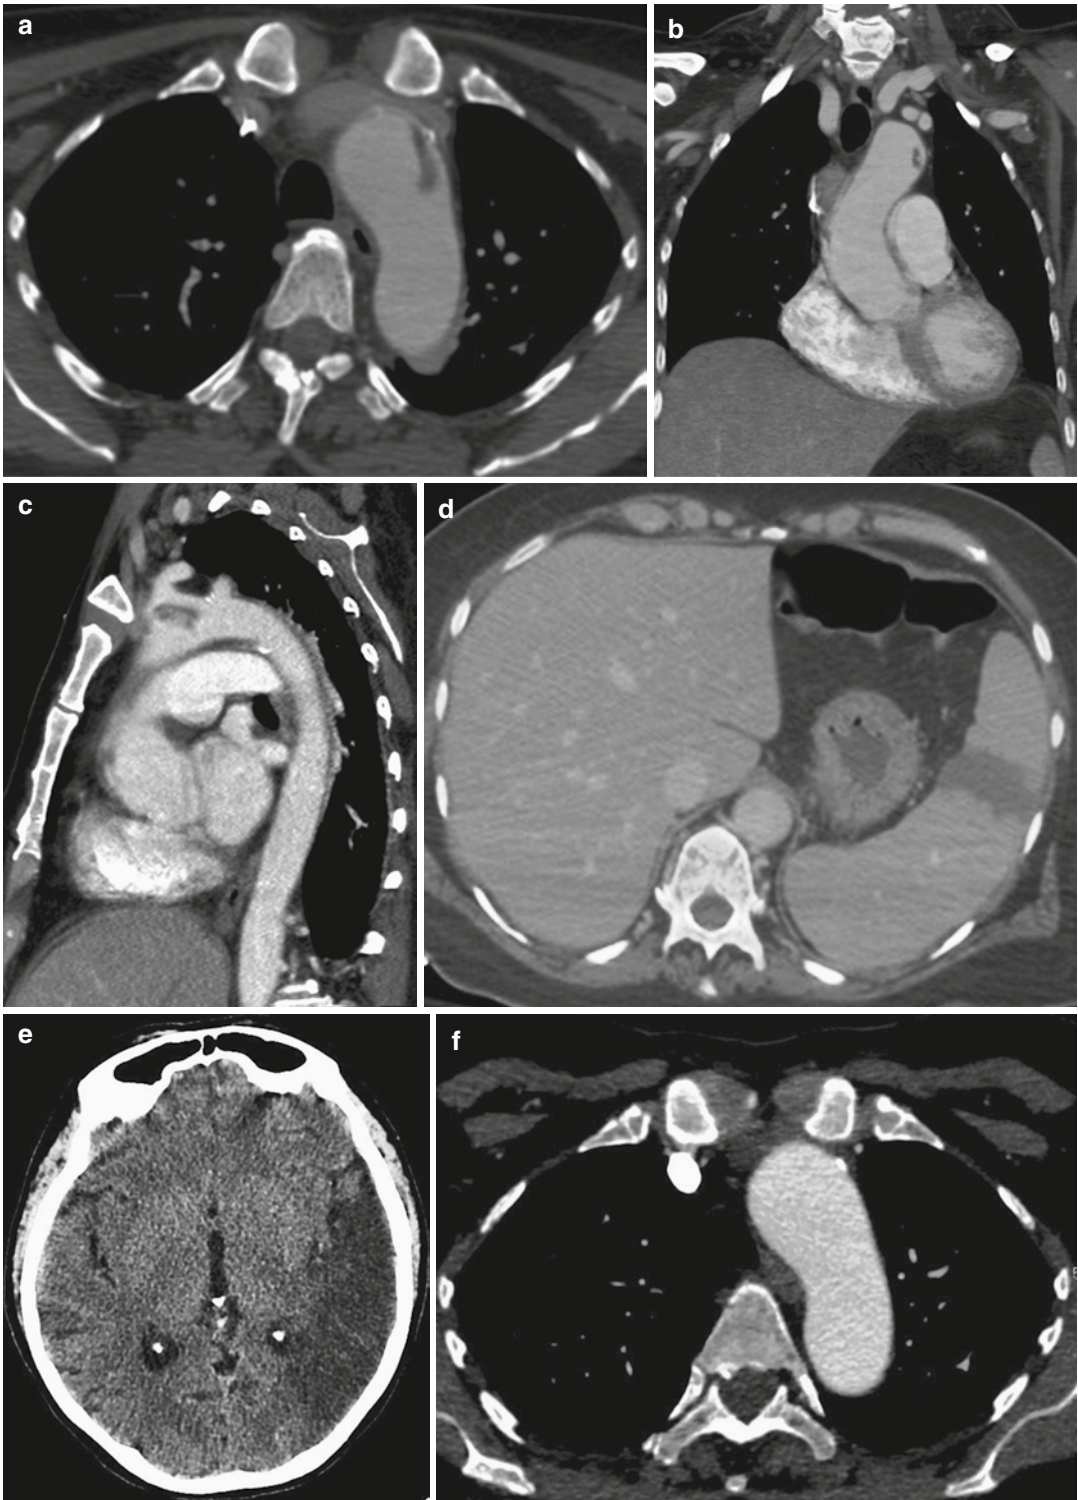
A 50-year-old woman presented to ED with abdominal pain. After a negative abdominal US, she developed aphasia and underwent head CT and TEE investigation. On the basis of TEE, thoracic aortic dissection was suspected. CT demonstrates a filling defect in a non-aneurysmatic
